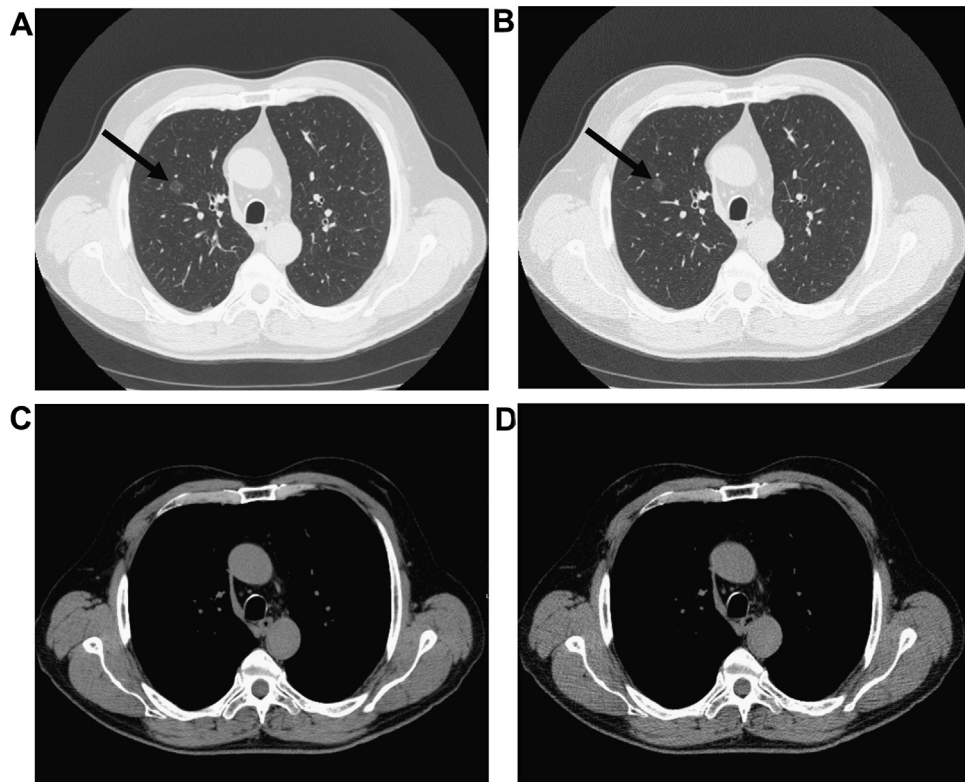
(a and c, standard dose images; b and d, low dose images) 76 year-old male (body weight 73 kg) who underwent chest CT as a follow-up study for a ground-glass pulmonary nodule. A purely ground-glass nodule in right upper lobe was clearly visualized both with standard dose CT and low dose CT (arrow).
